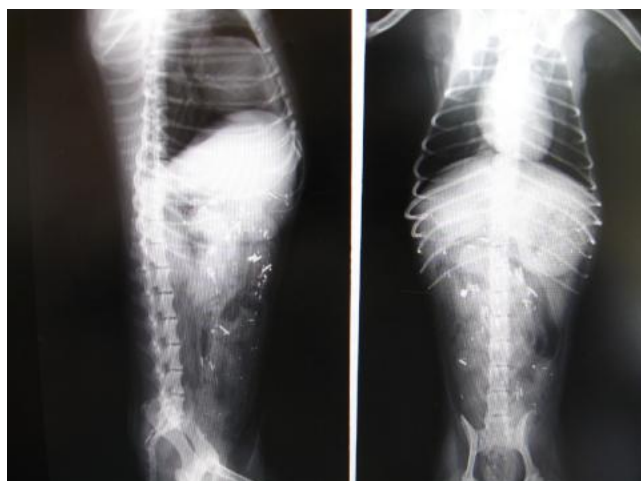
X-ray radiography of AIO.
